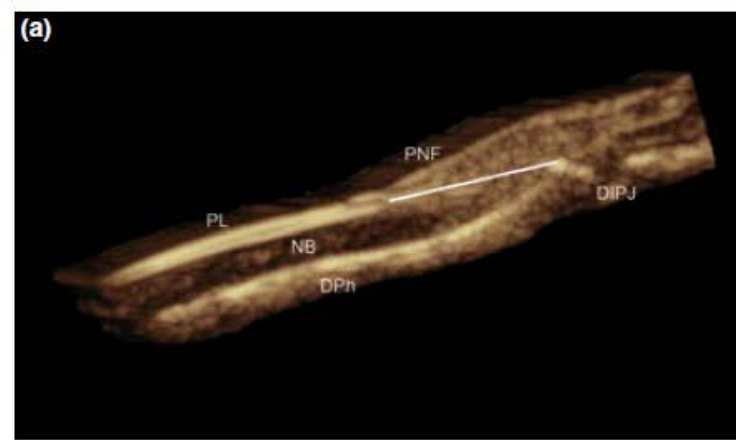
(a) 3D sonographic anatomy of the normal nail. Longitudinal axis reconstruction shows the normal structures that compose the nail unit. The white line indicates the normal distance between the origin of the nail plate and the base of the distal phalanx (distal interphalangeal joint level). (b) 3D sonographic imaging in retronychia. Longitudinal axis reconstruction shows thickening of the proximal nail bed and proximal nail fold. Notice the location of the origin of the nail plate closer to the level of the distal interphalangeal joint. The white line indicating the distance between the origin of the nail plate and the base of the distal phalanx is dramatically shortened. PL, plates; NB, nail bed; Dph, distal phalanx; PNF, proximal nail fold; DIPJ, distal interphalangeal joint.
